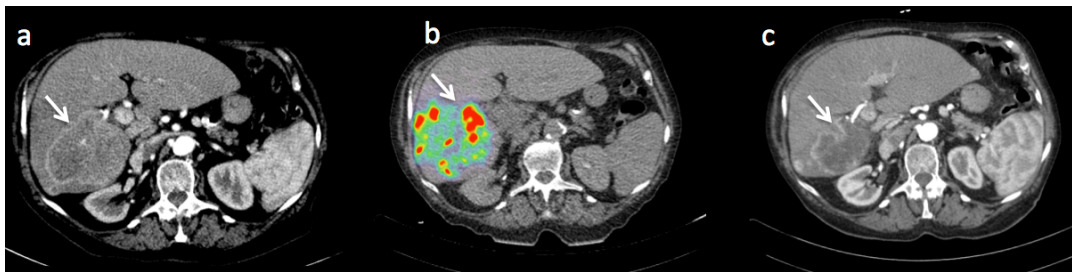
Example of large HCC lesion (white arrow) developed in the right liver on the arterial phase of the contrast enhanced CT scan (a). ^{90}Y PET/CT (b) obtained just after glass microsphere therapy demonstrated an excellent tumor uptake (TD=134 Gy, D₆₆=81 Gy). Four months later, the CT scan confirmed an excellent radiological response with a large tumor necrosis (c).
